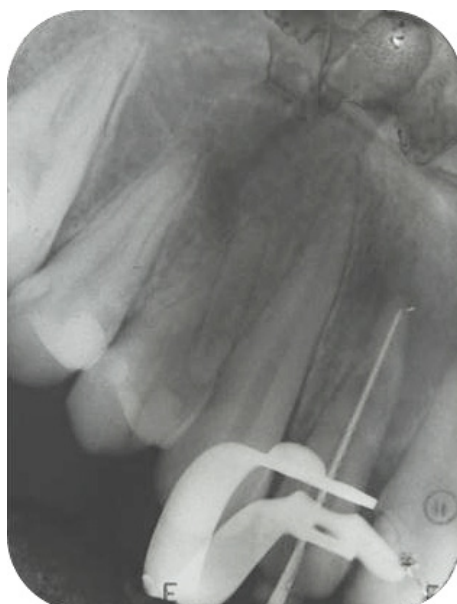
Periapical odontometry radiograph.
